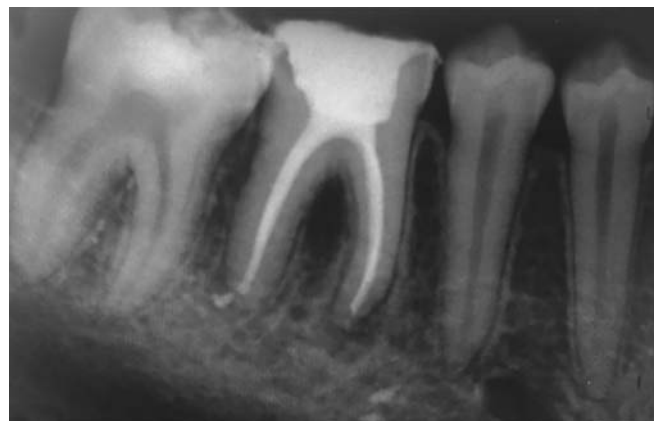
IOPA X-ray after placement of metapex intracanal medicament (IRT 46)
